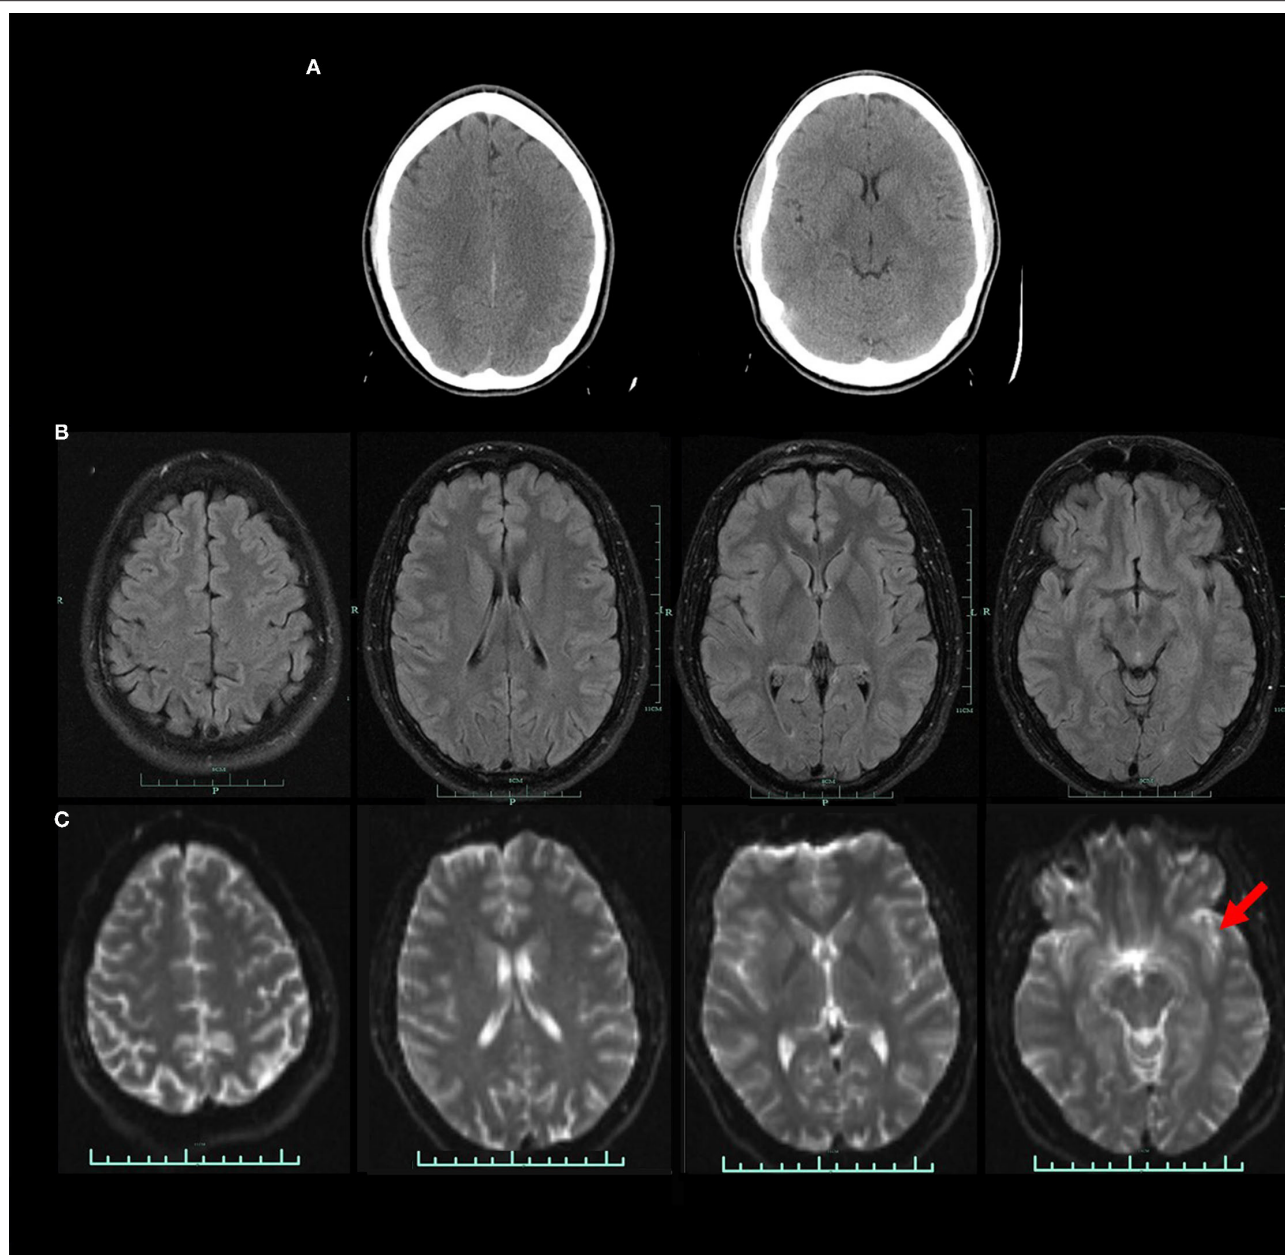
(A) CT scan at two levels obtained in the acute setting. CT read as normal. (B) FLAIR protocol MRI at four levels. No abnormality visible. (C) DTI MRI at four levels. A small area of high signal is noted in the left temporal lobe (red arrow).
